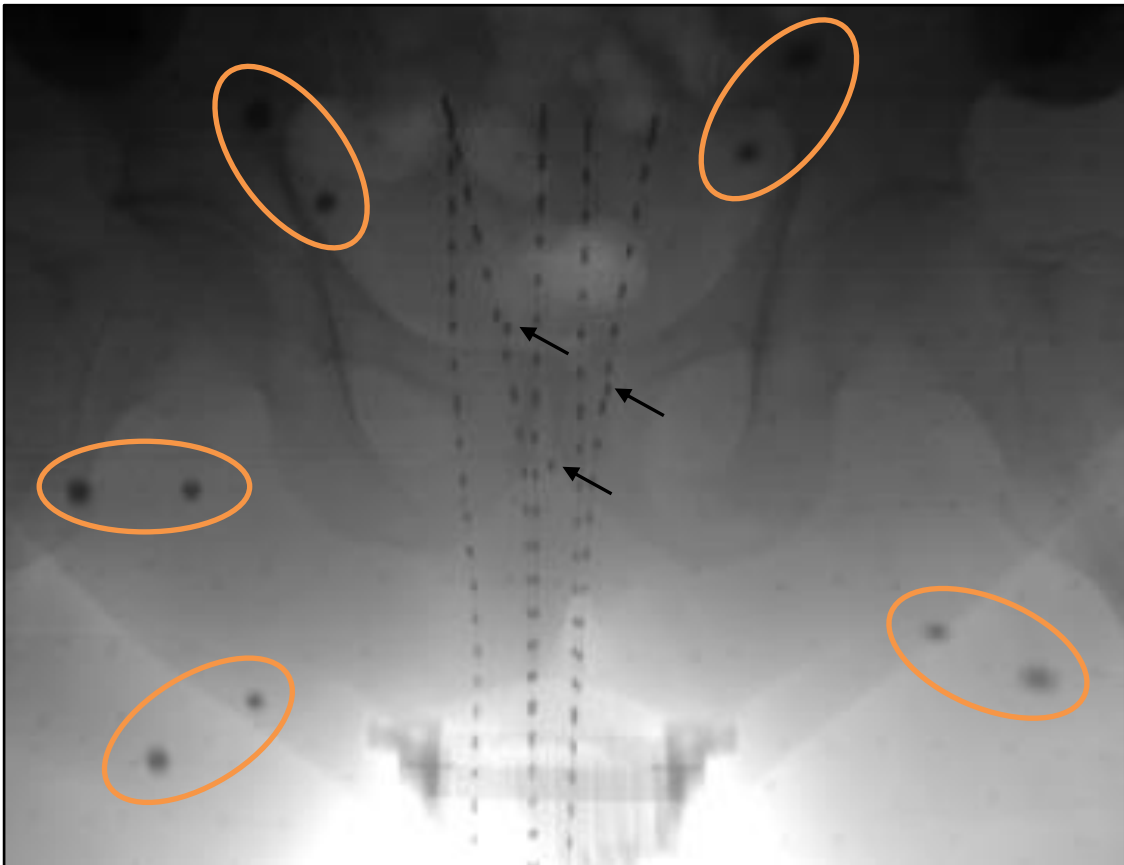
Pre-treatment A-P image acquired with the x-ray dwell position markers inserted into the specified catheters and the 5 BB array pairs (orange ellipses) in the field. The three fiducial markers implanted into the prostate are also visible (black arrows).
